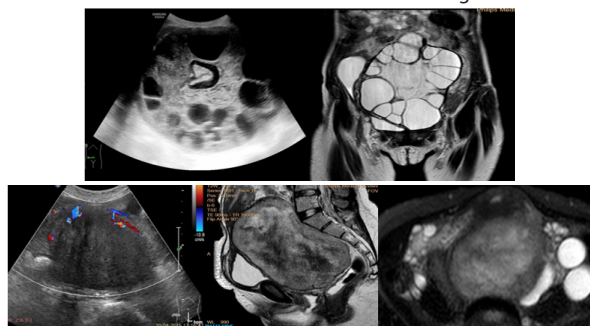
Broad Ligament Fibroid, here organ of origin was indeterminate on USG, which was confirmed on MRI to be extrauterine origin displacing uterus anteriorly.
